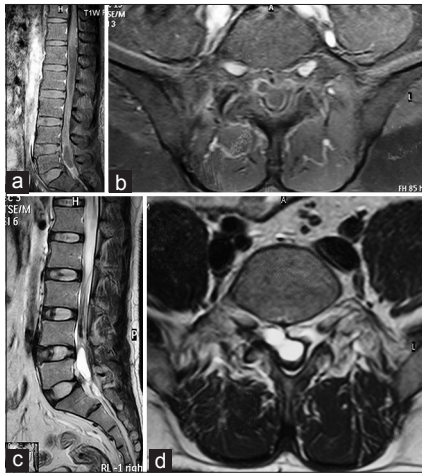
Magnetic resonance imaging of the lumbo-sacral spine. Contrast sagittal and axial T1-weighted images showing one cystic structures with an avid ring of enhancement at L5 level with displacement of the roots peripherally (a and b). T2-weighted images showing hyper intense lesion at L5 level (c and d)
